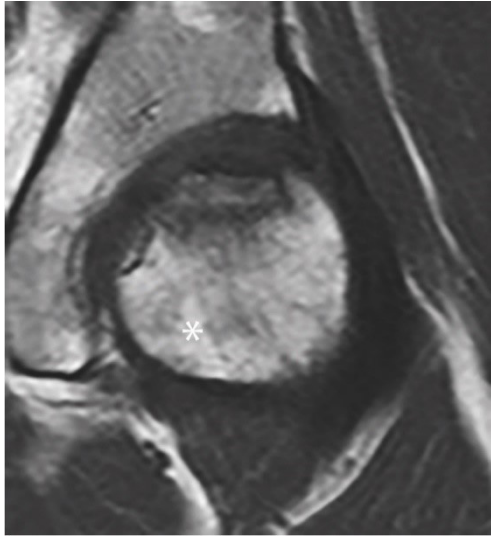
(A) A preoperative lateral view of the left femoral head. The posterior articular surface of the femoral head looks intact (asterisk). (B) An oblique axial view of magnetic resonance imaging. The posterior articular surface of the femoral head is confirmed to be intact (asterisk).
